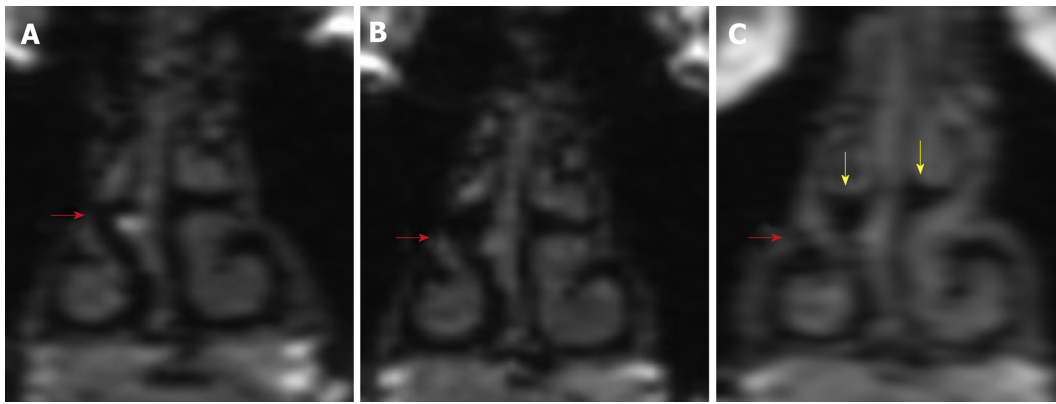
Comparison of coronal magnetic resonance imaging of nasal passages prior to and 1 year post regular stent use. A: Magnetic resonance imaging (MRI) from December 2015 prior to regular use of stents, without stents; B and C: MRI from June 2017 one year post regular use of AlaxoLito Plus stent (B: without stents *in situ*; C: with AlaxoLito Plus *in situ*).
